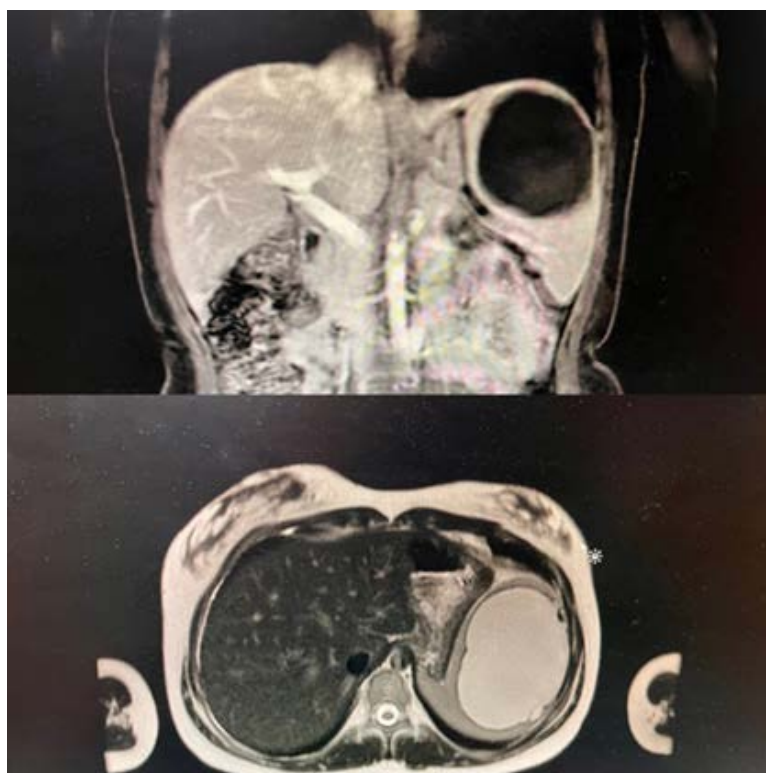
Magnetic resonance imaging – the first patient
